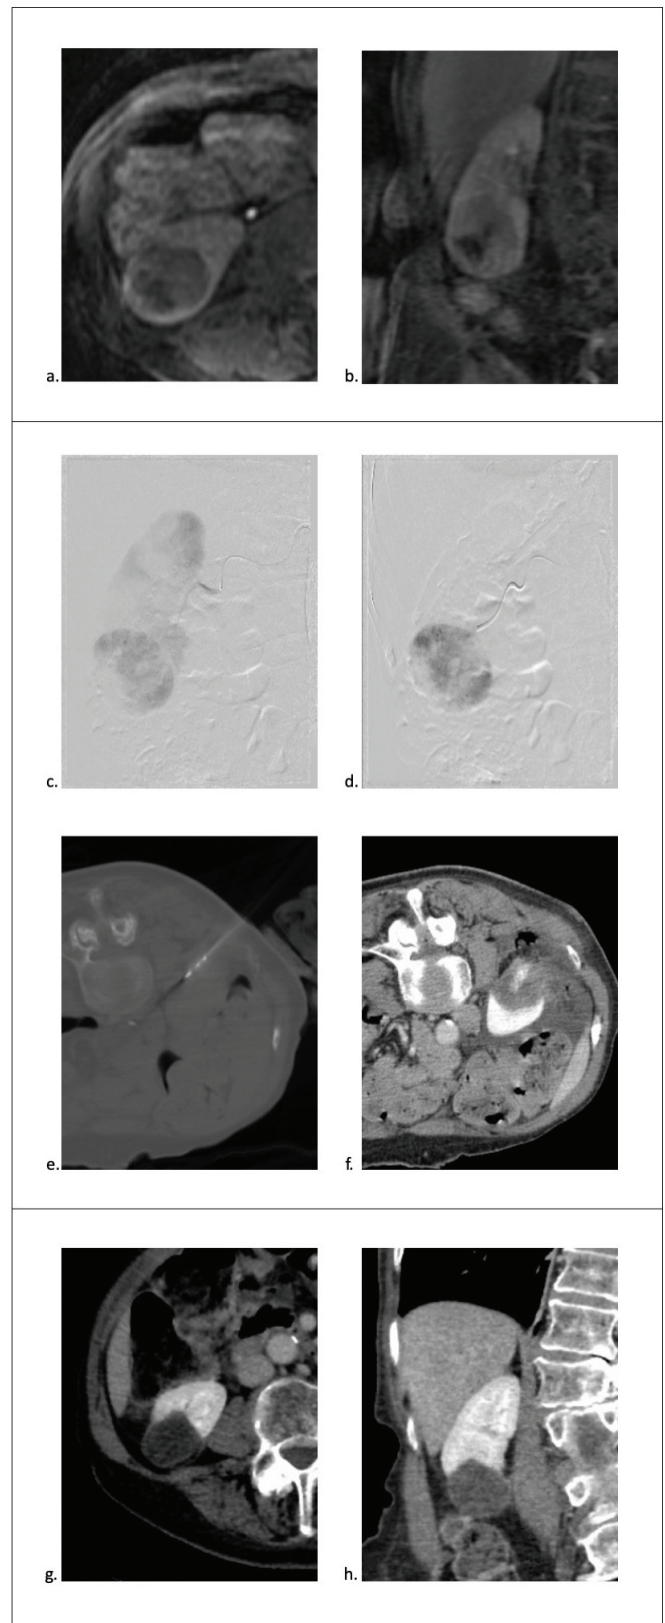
Imaging in 84-year-old female with dementia, leukemia, glaucoma, anxiety, depression, dysphagia and gastroesophageal reflux disease with 4.2-cm endophytic right lower pole renal mass. Contrast enhanced axial (a) and coronal CT (b) before embolization/ablation demonstrates mass. c, intraoperative DSA of right renal artery. d, DSA of segmental artery to lower pole mass during embolization. e, post-embolization placement of microwave ablation probe. f, post-ablation CT shows successful ablation of renal mass. At 12.5 months postoperatively, contrast enhanced axial (g) and coronal CT (h) reveal successful treatment of renal mass.
